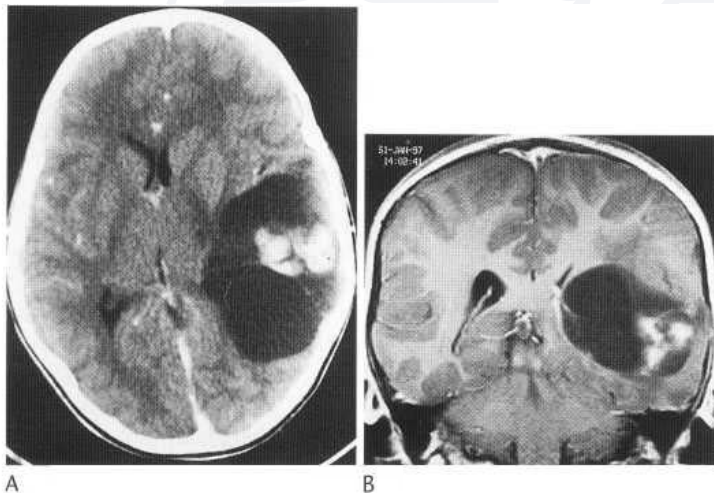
A large complex mass in the left cerebral hemisphere shown on this postcontrast CT (A) and coronal T₁-weighted MR image (B) was proven to be a pleomorphic xanthoastrocytoma. It has a large cystic component and the peripheral lobulated solid component shows marked enhancement. Some focal resorption of the overlying skull vault is shown on the coronal MR image.
